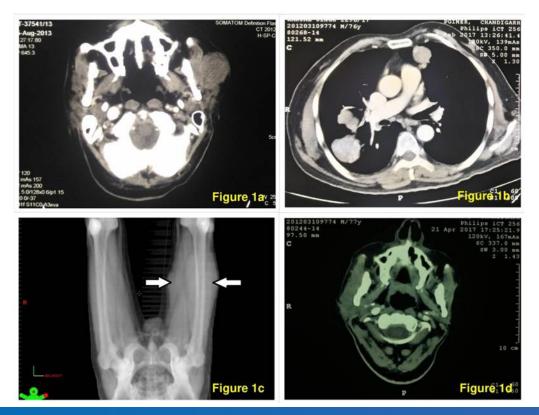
Figure 1a: Preoperative CT image of parotid tumor; Figure 1b: CT slice showing lung metastases; Figure 1c: CT of limbs (thigh metastases shown by white arrows); Figure 1d: Latest CT image showing no evidence of recurrence in primary site.
